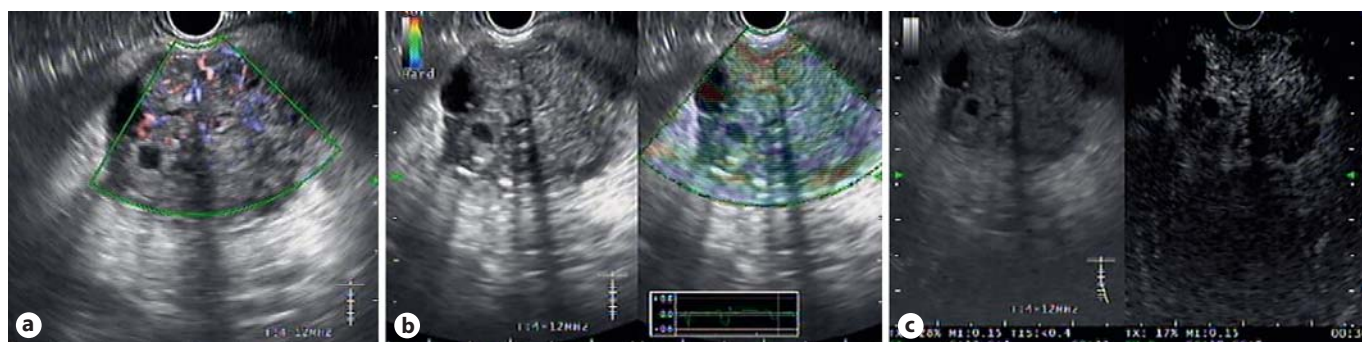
Endoscopic ultrasound: 45-mm hypoechoic pseudo-solid lesion, with an intense Doppler signal (a), a soft (predominantly green) pattern on elastography (b), and an intense enhancement with late washout in the dynamic study with contrast (c).
